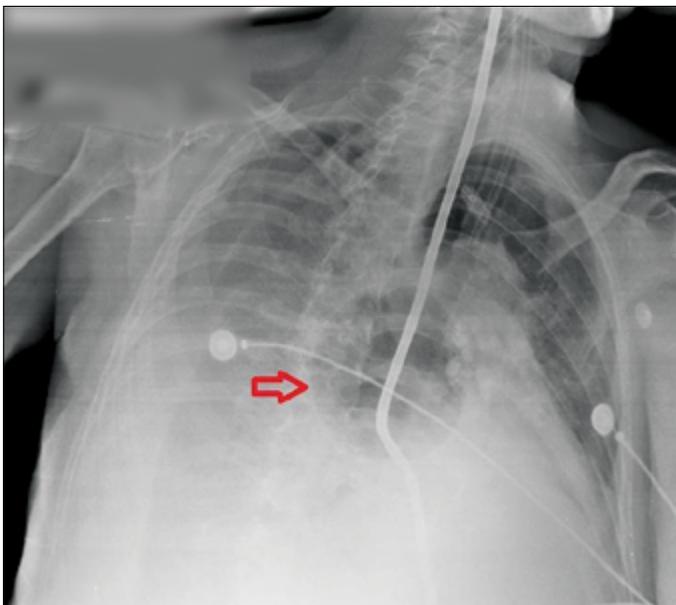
Chest X-ray showing the gastric balloon of the SBT behind the cardiac silhouette (*arrow*)
